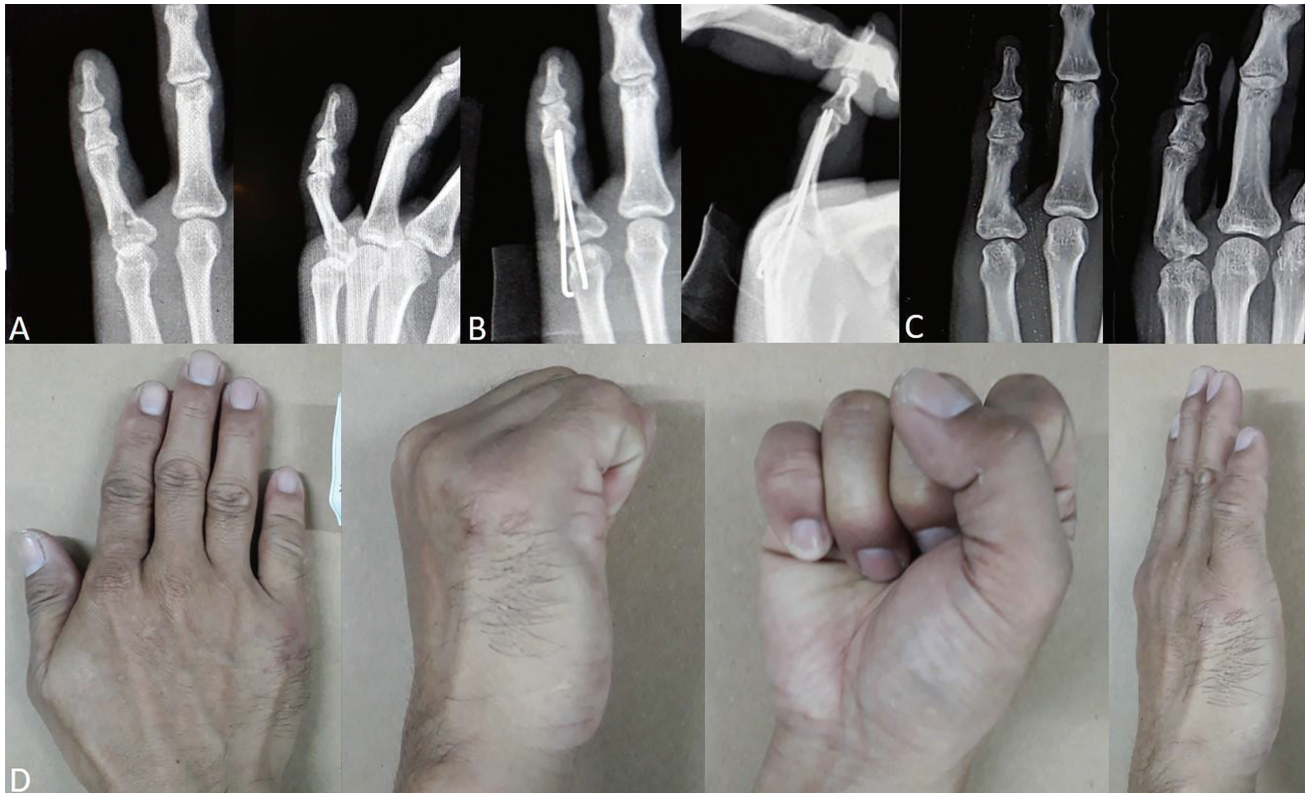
Patient 24 with small finger proximal phalangeal fracture. Injury radiograph (A), immediate postoperative radiograph (B), radiograph at 12th week follow-up (C), range of motion at 12th week follow-up (D).
